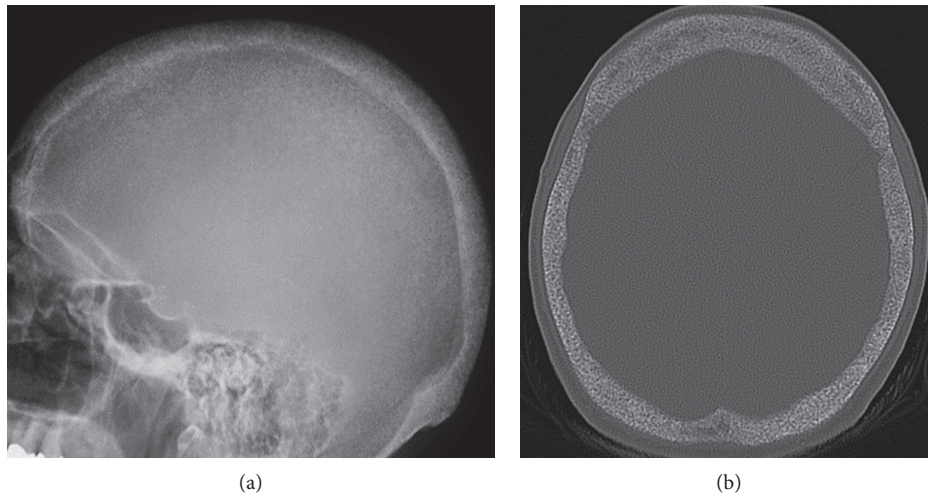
"Salt-and-pepper-skull." Lateral skull X-ray and axial bone windows CT with salt-and-pepper appearance from trabecular bone resorption depicted as fine areas of lucency mixed with sclerotic radiopaque-dot-like foci.
